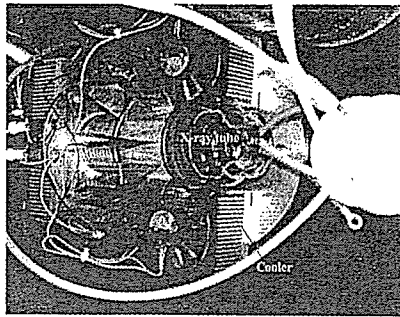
X-ray tube unit with coolers.
